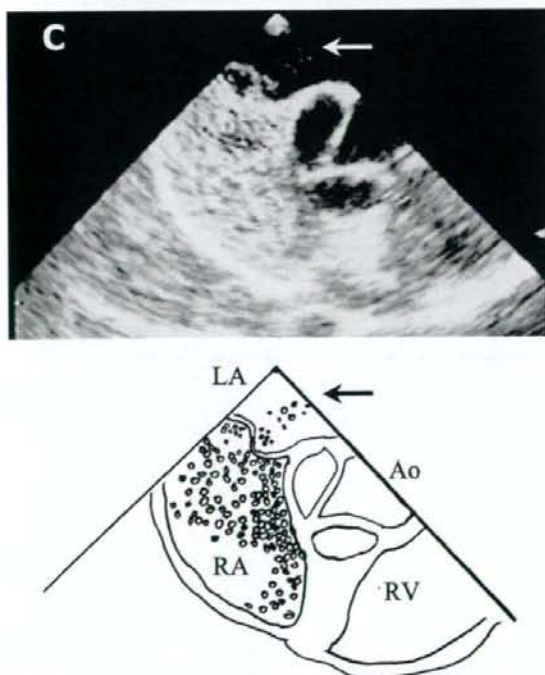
Contrast transesophageal echocardiographic examination. Microbubbles fill the right atrium and appear in the left atrium through a patent foramen ovale without Valsalva maneuver (arrow). LA, left atrium; RA, right atrium; RV, right ventricle; Ao, aorta.
